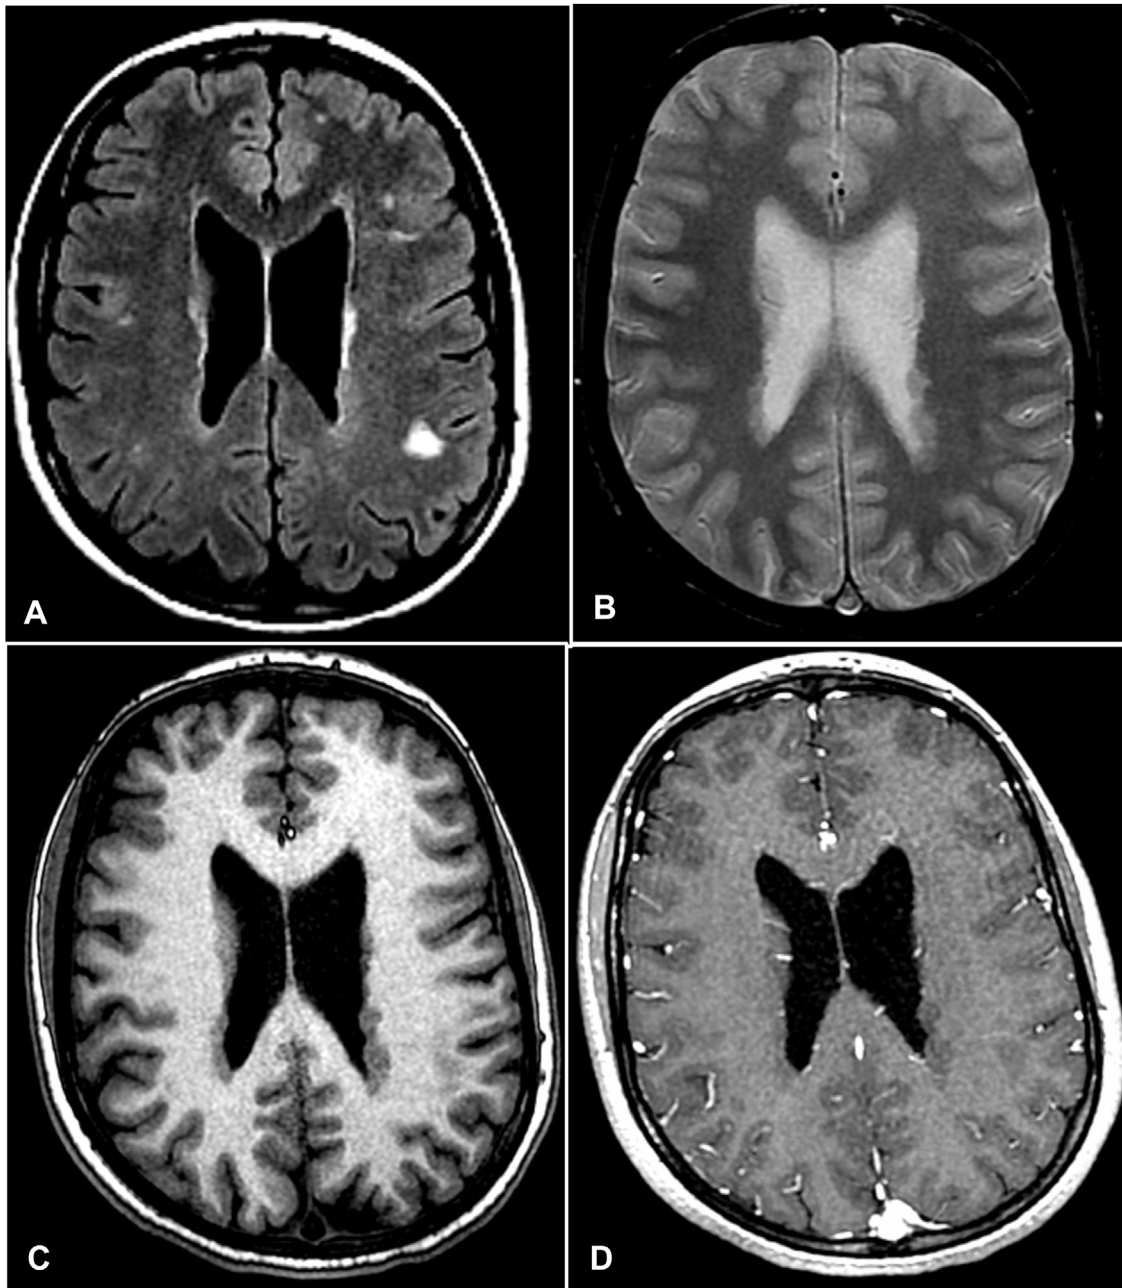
A) FLAIR sequence showing subcortical hyperintensities, some of them isointense with the cerebral cortex; these findings were also observed on the proton density-weighted sequence (B). C) T1-weighted sequence showing periventricular lesions corresponding with isointense nodular images in the cerebral cortex, without gadolinium uptake (D). The periventricular findings are highly indicative of periventricular cortical heterotopia, whereas the hyperintense subcortical lesions on FLAIR sequences present non-specific characteristics and are not conclusive for the diagnosis of multiple sclerosis.
